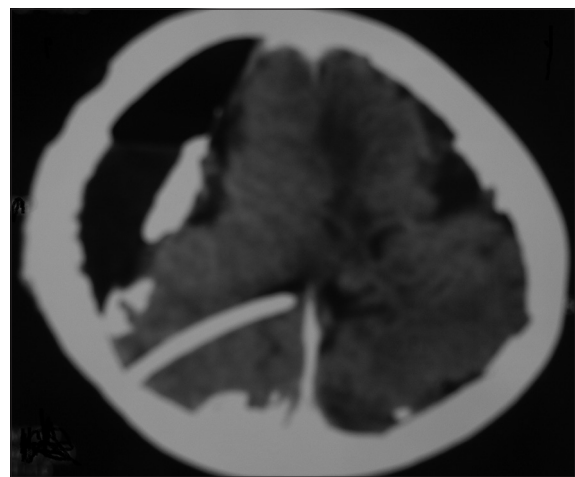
Computed tomography scan of the head of an 8-year-old boy showing asymmetrical bilateral frontoparietal calcified chronic subdural hematoma following ventriculoperitoneal shunt surgery. The calcification was more marked on the right side compared to the left-sided (a) axial section (b) coronal section formatted image, and (c) sagittal reconstruction
